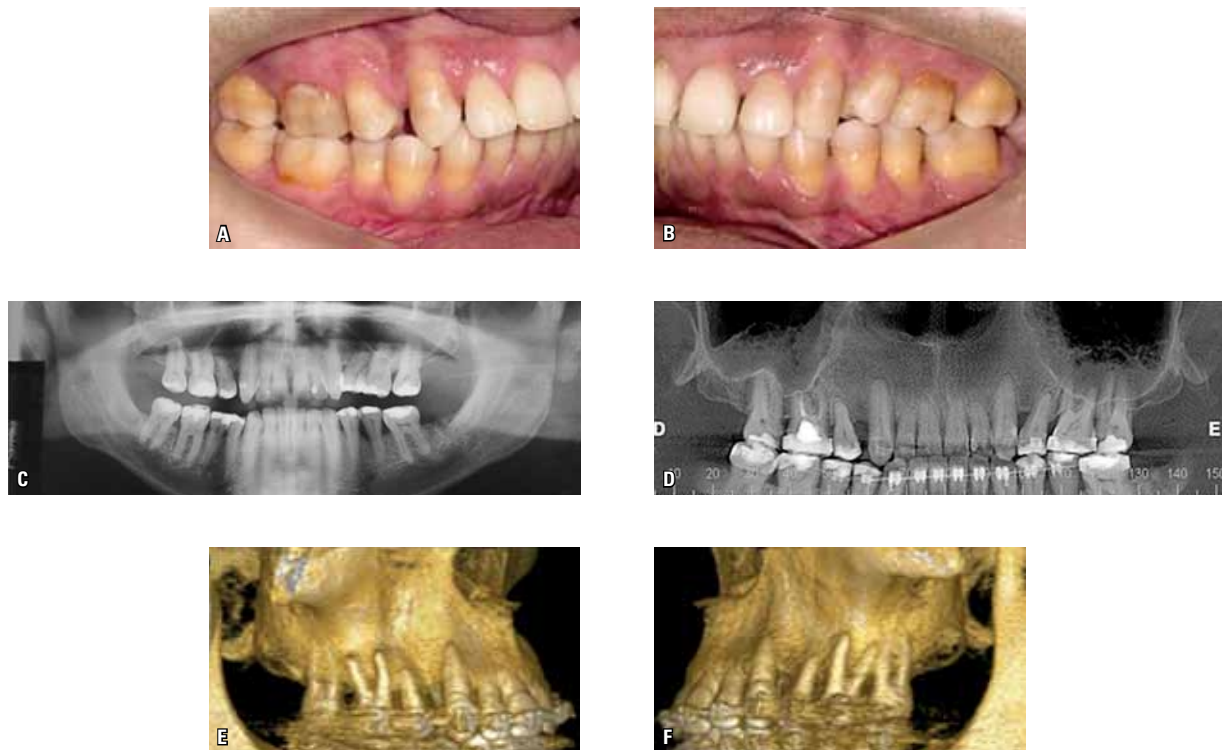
A, B) Detail of the region of anterior teeth and diastema between teeth. C) Initial panoramic radiography. D) CBCT showing uniform horizontal bone loss and root resorption of the elements 11, 12, 13, 15, 21, 22, 23 and 25. E, F) CBCT reconstruction (right and left). Note the horizontal alveolar bone loss and dehiscence in buccal roots of the elements 23, 26, 16 and 13.
